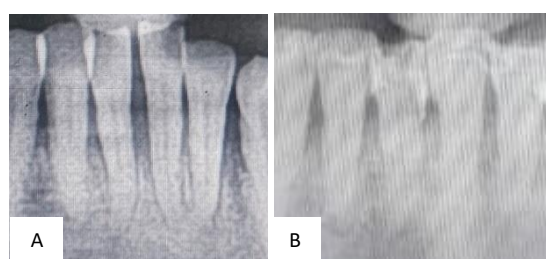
Comparison of the initial condition radiograph A. with the final condition B.
